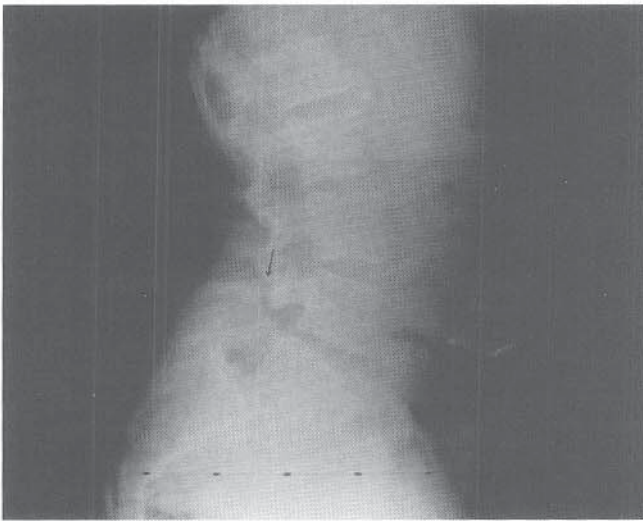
Radiographic appearance in an 18-year-old man who represented with the new onset of back pain 3 years after successful L5–S1 fusion for low-grade spondylolisthesis. An L4 stress fracture can be seen above the fusion mass.
